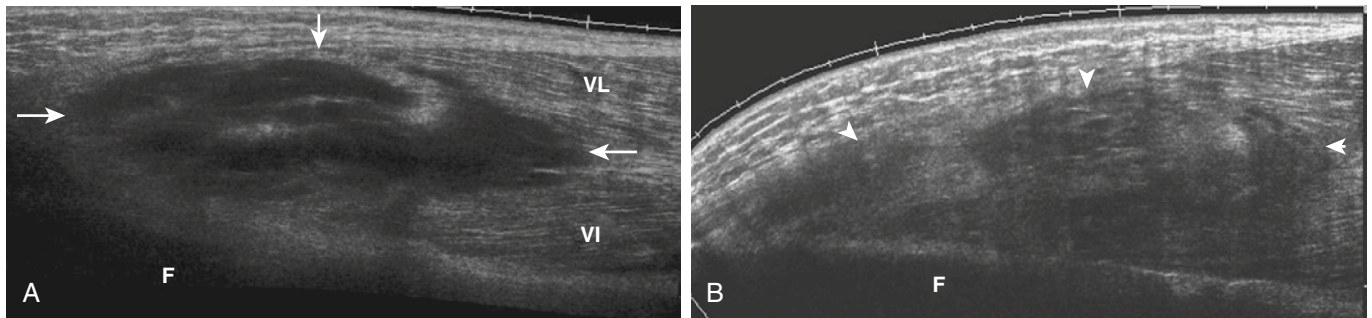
A soccer player had a contusion after an impact to the lateral thigh. A, Longitudinal panoramic view 1 day after the injury shows the femur (F) and a large, complex, hypoechoic hematoma (*arrows*) involving vastus intermedius (VI) and vastus lateralis (VL). B, Longitudinal panoramic sonogram 14 days after injury shows a reduction in swelling and replacement of the hematoma by echogenic muscle and granulation tissue (*arrowheads*).
